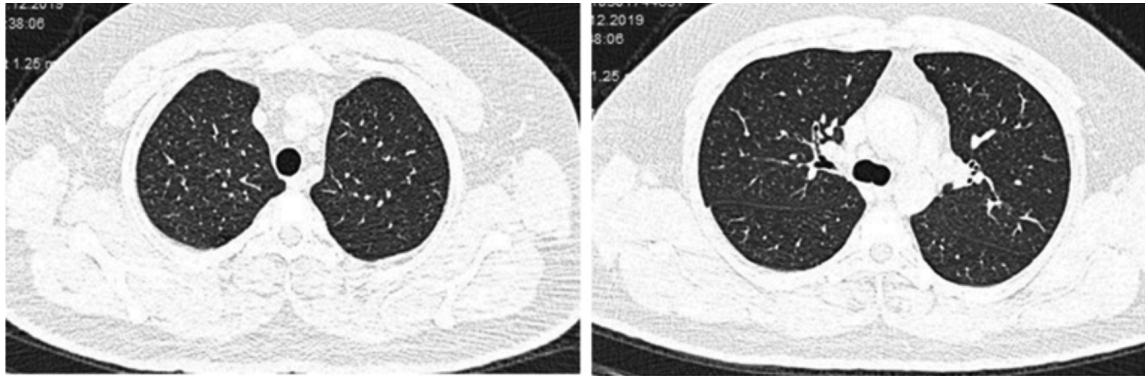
High-resolution computed tomography of chest of a patient with pneumoconiosis
